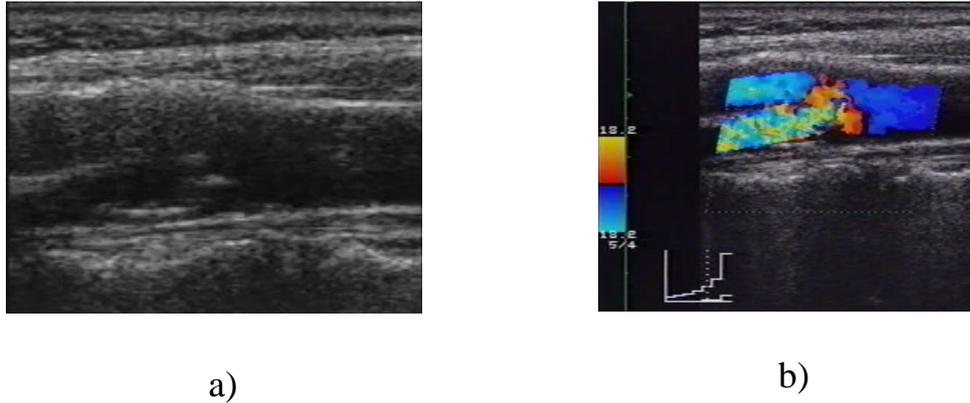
Ultrasound tomographic scan
